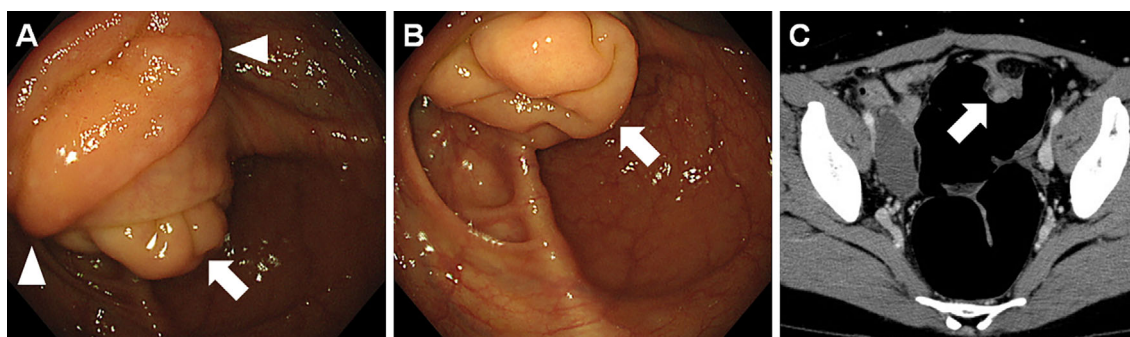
Colonoscopy and CT images of Case 2. Colonoscopy revealed a subepithelial tumor in the cecum (A, B, arrows). The Bauhin's valve had been deformed due to the tumor (A, arrowheads). Contrast-enhanced CT with colorectal carbon dioxide insufflation revealed a cecal tumor with partial enhancement (C, arrow). The fat tissue seemed to have folded up into the tumor.
